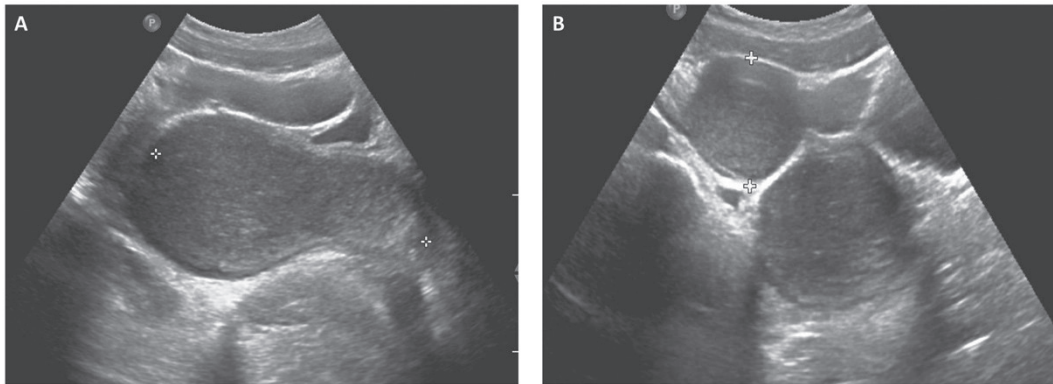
Pelvic Ultrasound in longitudinal (A) and axial (B) views.
